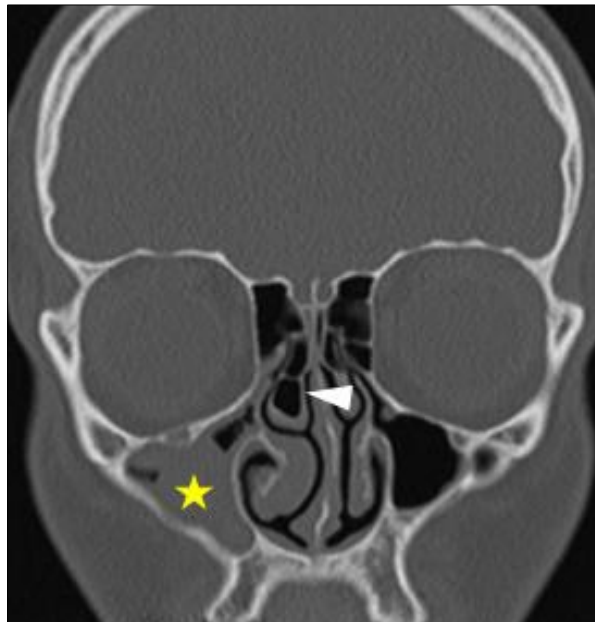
Coronal CT section showing right sided large concha bullosa (White arrow head) and right left maxillary sinusitis (Yellow star)
